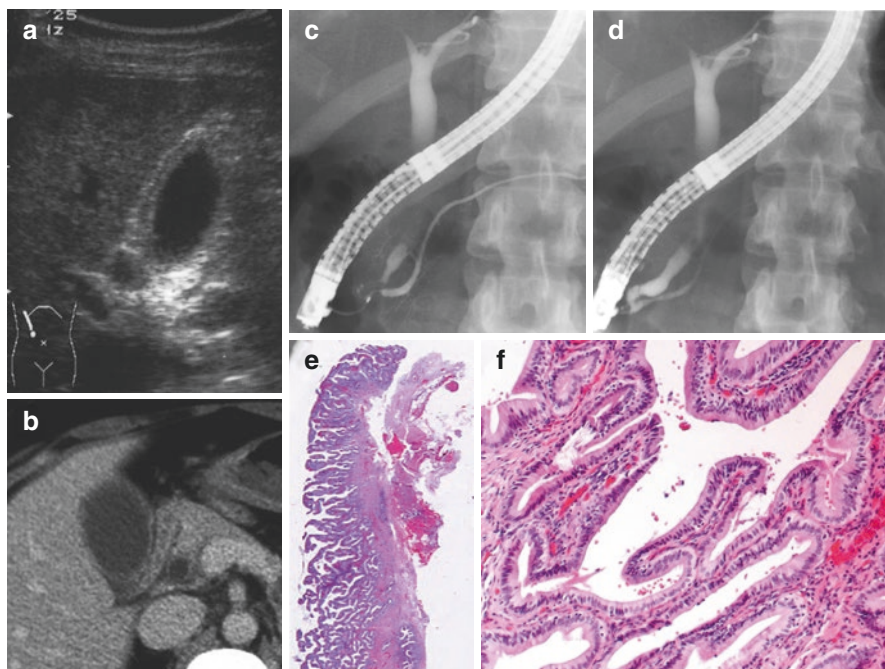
A case of HCPBD without dilatation of the common bile duct (31 years old, female). The gallbladder wall thickening in the inner layer was detected in US (a) and enhanced CT (b). A cholangiopancreatography was obtained from a long common channel using an ERCP catheter (c). After removing a catheter, pancreaticobiliary reflux was detected via a long common channel during sphincter relaxation (d). Hyperplastic change was found in the gallbladder mucosa (e, f)
